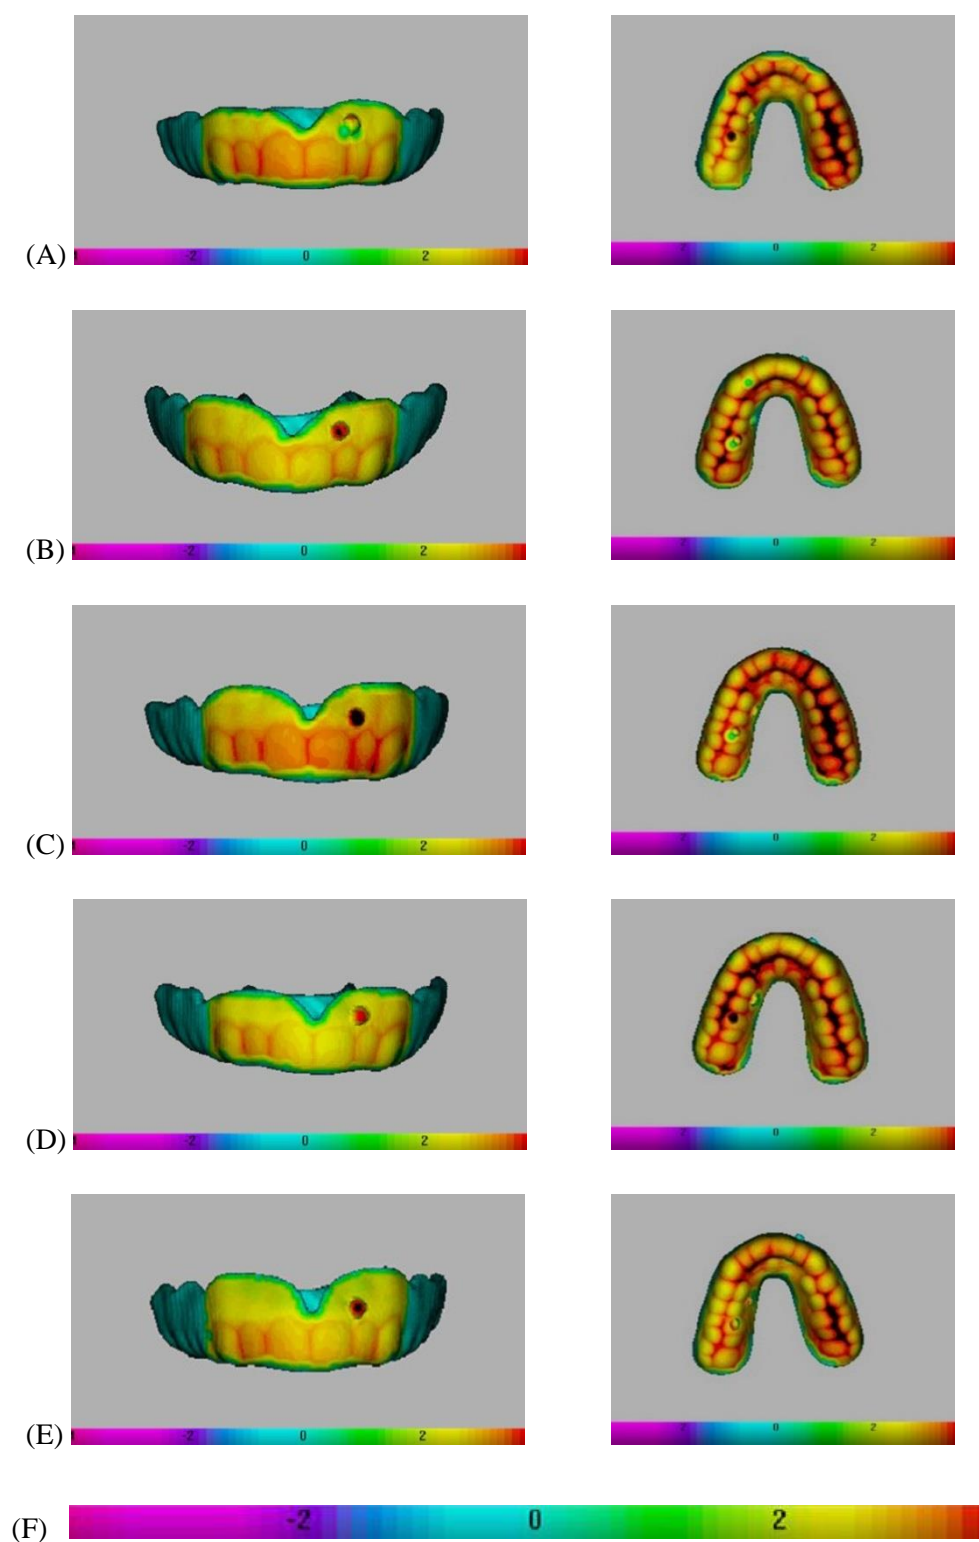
A-E: CT scanned images of the two surface areas within the five thickest mouthguards. (F) Shows an enlarged thickness/colour key, 0 mm to ± 4 mm.
